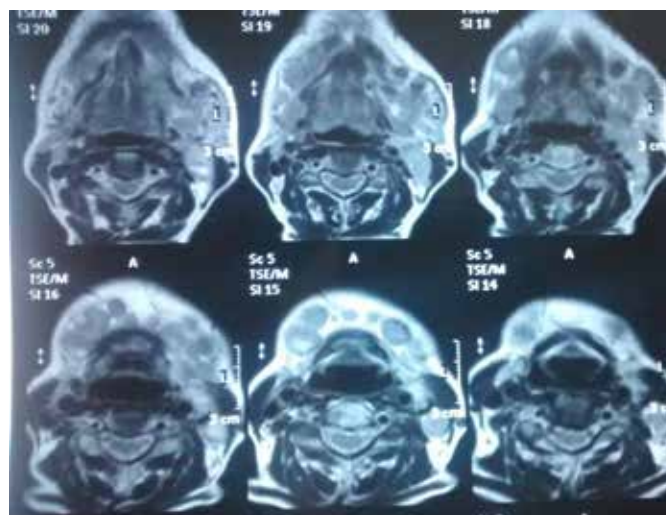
MRI image of the lesion
